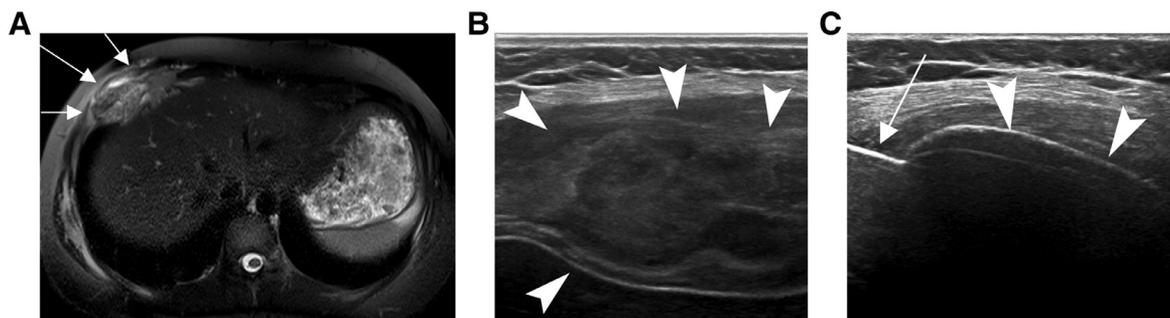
A 14-year-old girl with a history of metastatic osteosarcoma presents with focally painful lesions of her right ribs. Axial T2-weighted MR image (A) demonstrates an edematous, expansile, destructive lesion (white arrows) of the right 10th rib anteriorly. Gray-scale ultrasound image (B) demonstrating the same lesion (white arrowheads), which appears lobular and heterogenous. Intraprocedural gray-scale ultrasound image (C) demonstrating placement of the cryoprobe (white arrow) within the lesion after formation of the iceball (white arrowheads).
